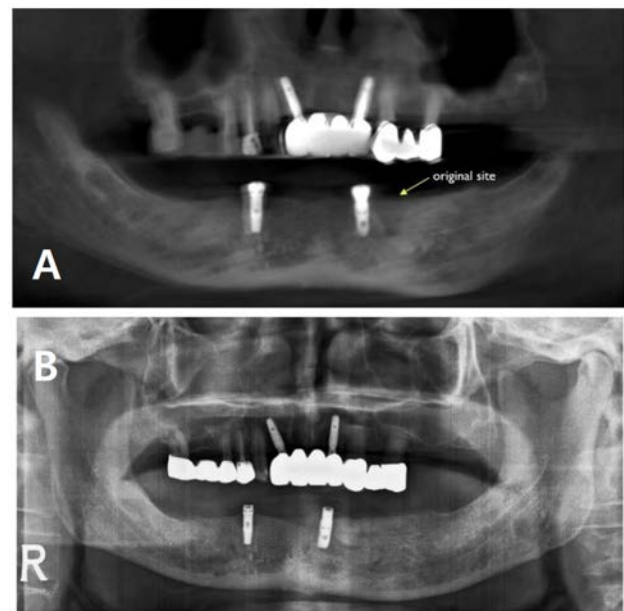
Panoramic radiograph. (A) Implant installation in another site (#32 site). (B) 2 years after the prosthetic treatment.
